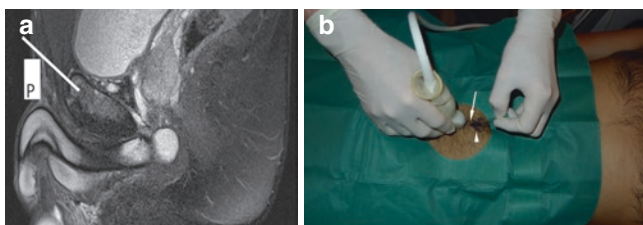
(a) Sagittal PDw MR image shows probe position (P) and superior needle approach (*line*). (b) Operator scanning sagittally in aseptic field having marked superior end of the probe (*arrowhead*) with needle entry into the unmarked skin between the mark and probe
